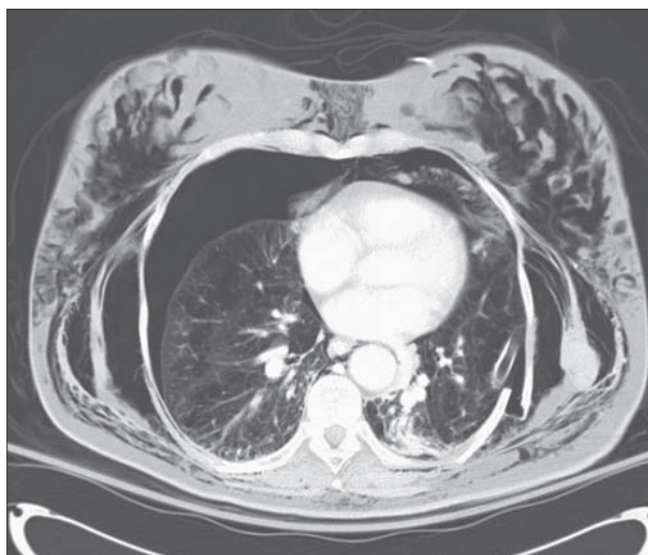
Noncontrast CT scan of chest also showing bilateral pneumothoraces with shift. The thoracostomy tube is present on the left, and the displaced posterolateral rib fracture is seen on the left. Subcutaneous emphysema is tracking through multiple planes.
